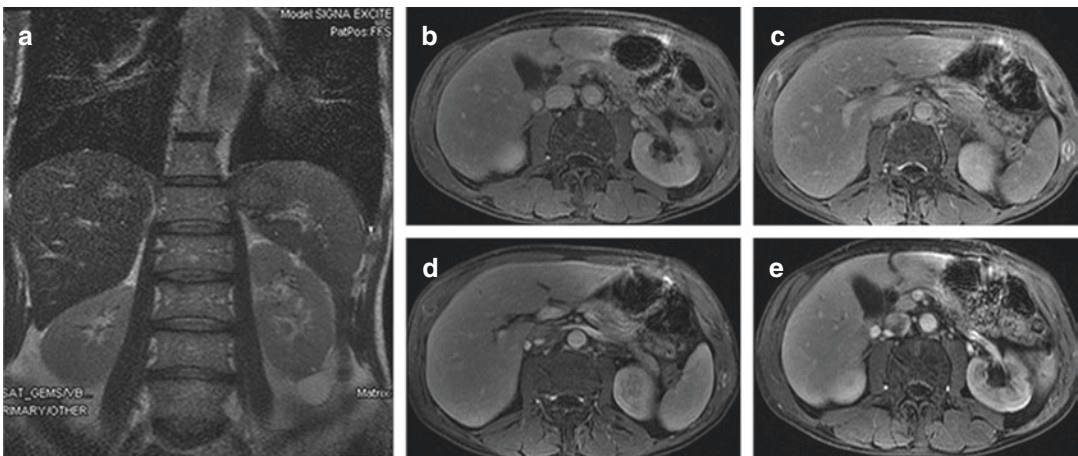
(a–e) VIBE T₁-weighted image after contrast media administration. MRI follow-up after 1 month shows complete resolution of the splenic lesion; on the superior pole of the kidney a very small hypointense area remains, referred to as scar tissue
